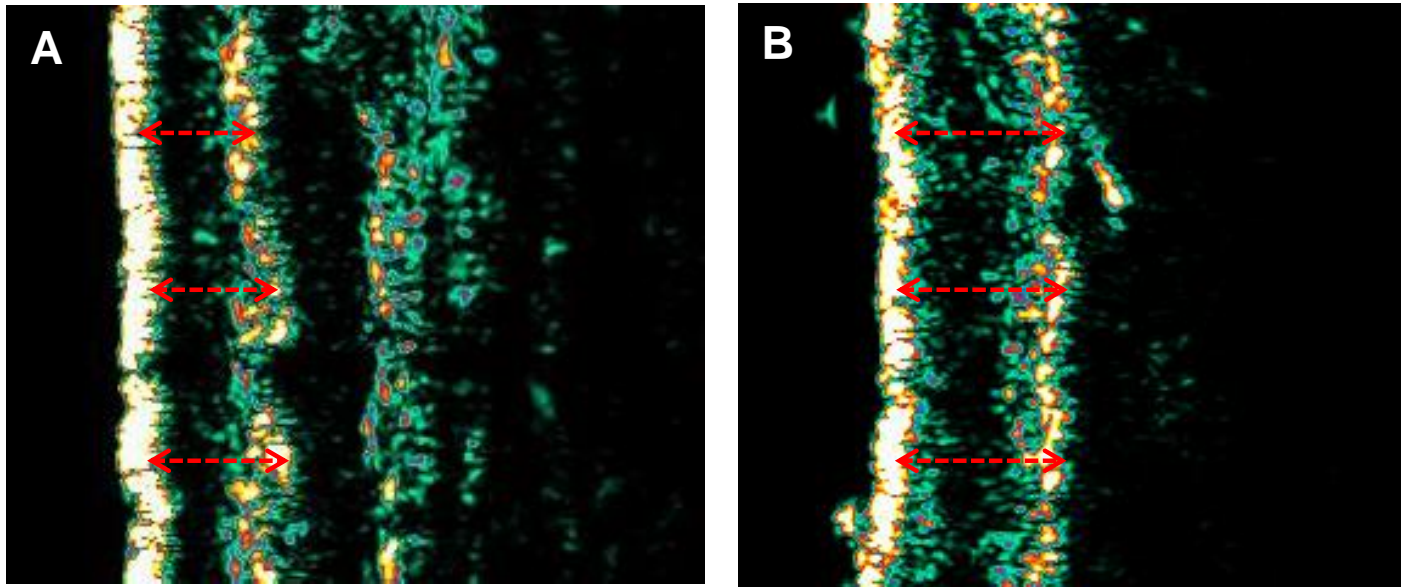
Dermis thickness of the posterior forearm measured by 20-MHz ultrasound scanner. (A) 0.64mm thickness in an elderly patient with skin tear (84-year-old, female), (B) 0.89 mm thickness in an elderly patient without skin tear (94-year-old, female). The dermis thickness was measured at three regular sites (red arrows) over the width of one image from under the epidermis to the interface between the dermis and the subcutaneous tissue.
